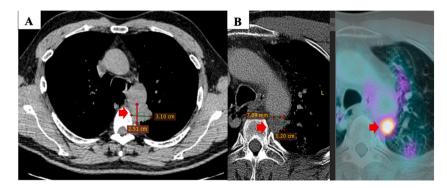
CT scan examination of the primary tumor at the first time of diagnosis (A). PET/CT scan examination of the primary tumor after the first-line treatment (3 cycles of carboplatin 650mg (AUC5) plus paclitaxel 300 mg (175mg/m<sup>2</sup>) in combination with radiotherapy at the third cycle) (B).
